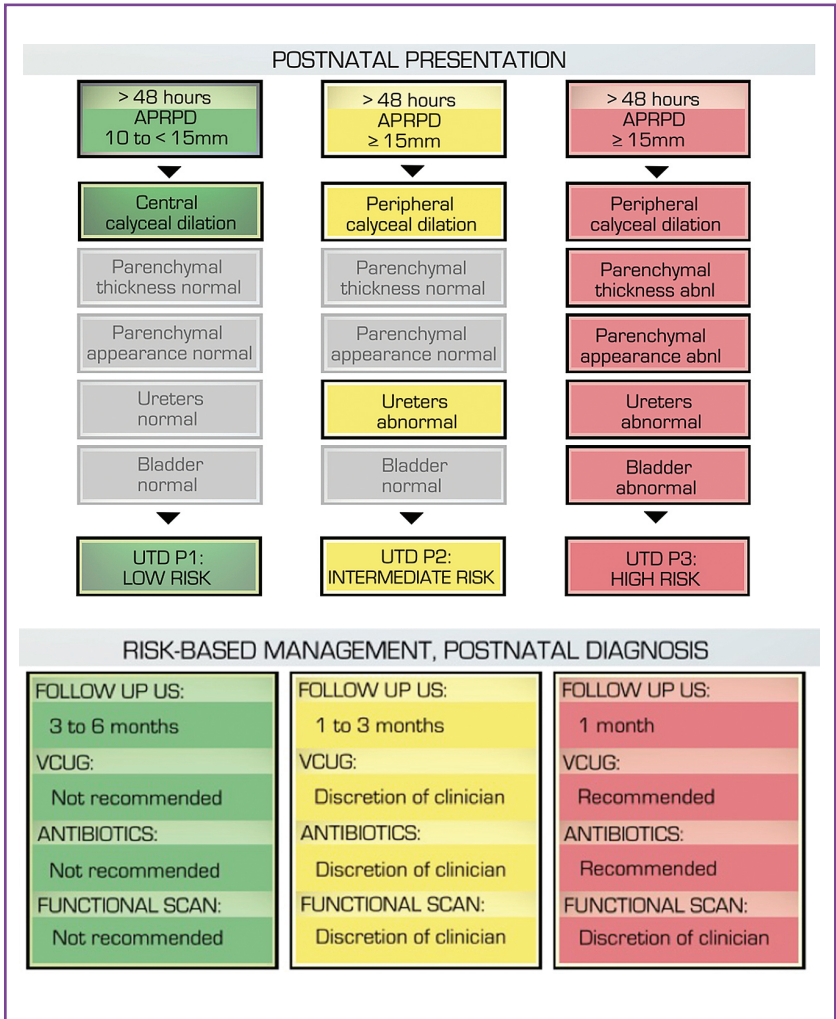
Urinary tract dilatation (UTD) postnatal risk stratification and risk-based management. Postnatal UTD grade P1 indicates low risk, UTD grade P2 indicates intermediate risk, and UTD grade P3 indicates high risk. Stratification is determined by the most concerning ultrasonographic finding. APRPD, anteroposterior renal pelvic diameter; US, ultrasonography; VCUG, voiding cystourethrography.
